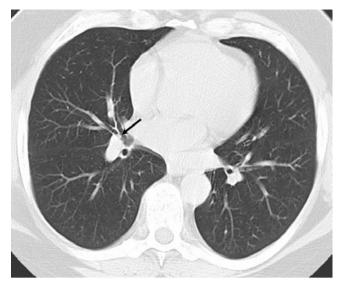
Perception is important in CT of the endobronchial lesion. Axial CT image shows a tiny endobronchial nodule (arrow) in distal right middle lobe bronchus. Bronchoscopic biopsy showed a polyp with squamous metaplasia
